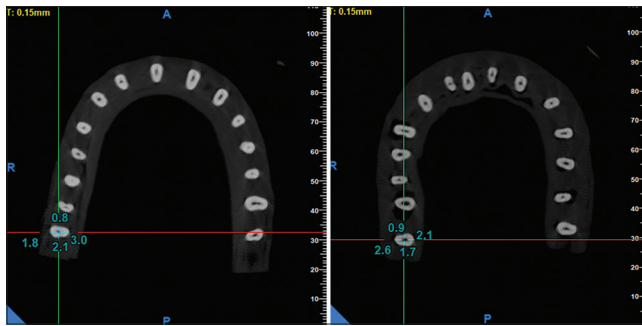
Preoperative and postoperative measurement of remaining dentin thickness of CBCT imaging
